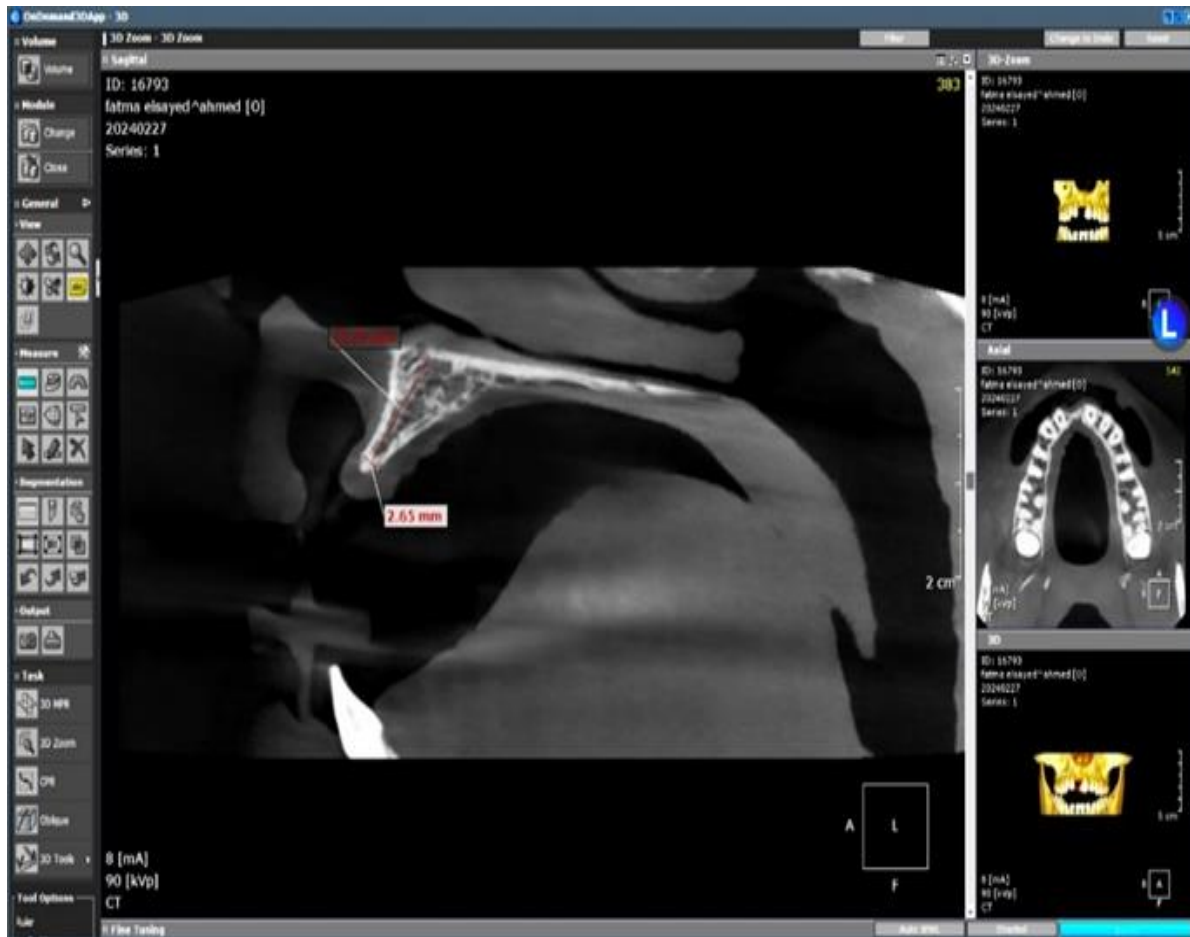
Preoperative CBCT scan
